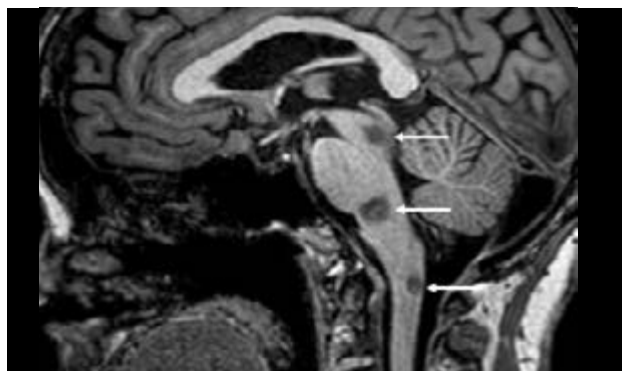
MRI of a 67-year-old woman presenting with left-sided hemihypoesthesia and hemiparesis, together with cranial neuropathy and cerebellar ataxia. Sagittal T1WI showing hypointense focal lesions involving the midbrain, pontomedullary junction, and spinal cord (arrows).
